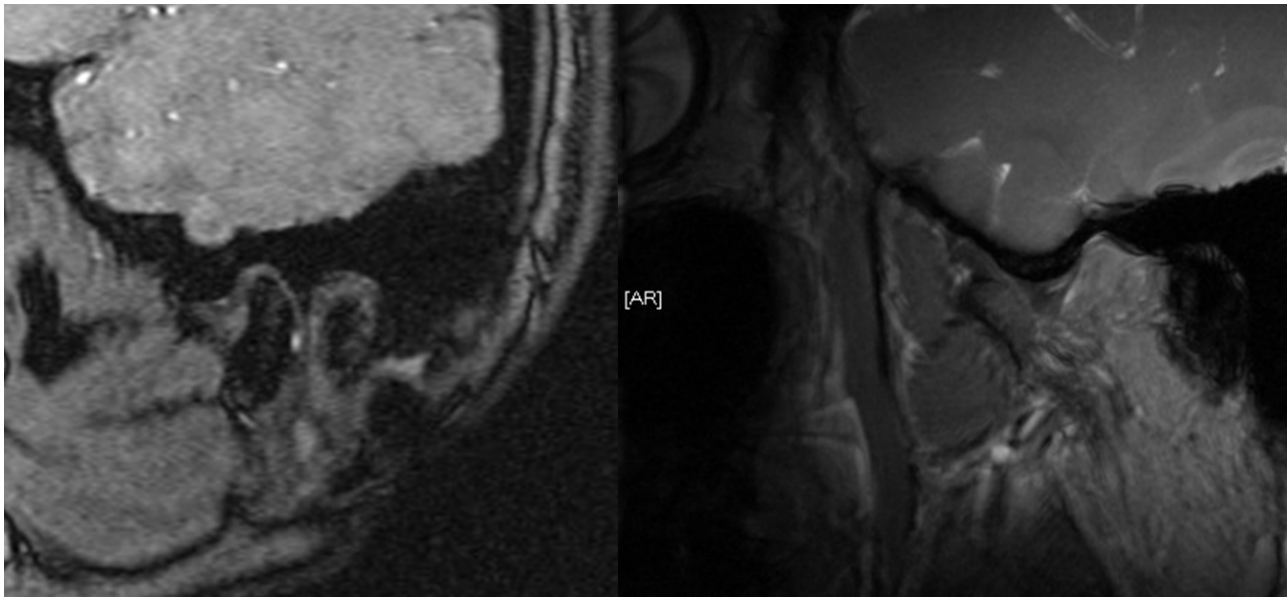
Sagittal sectional views of TMJ on mouth-closed T1-weighted and mouth opened T2-weighted MRI show anterior disc displacement without reduction (white arrows).
